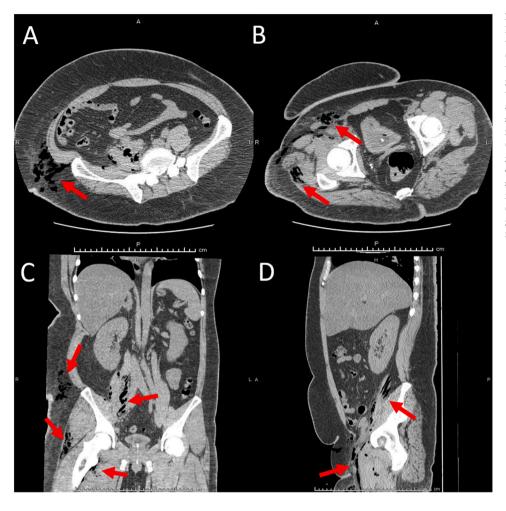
Plain CT taken on hospital day 1, (A) Horizontal section of the pelvic CT shows gas in the adipose tissue of the right inguinal region (arrow). CT attenuation value of the subcutaneous adipose tissue is increased around the gas. These findings are consistent with necrotizing fasciitis. (B) Horizontal section of the CT at the level of the femoral head shows widespread gas around the right gluteus medius muscle and the right iliacus muscle (arrows). (C) Coronal section of the CT shows widespread gas from the inside of the right femur to subcutaneous tissue over the superior anterior iliac spine, and from the muscles around the right femur to the right iliopsoas muscle (arrows). (D) Sagittal section of the CT shows widespread gas from front of the right quadriceps femoral muscle to the right iliopsoas muscle (arrows).
